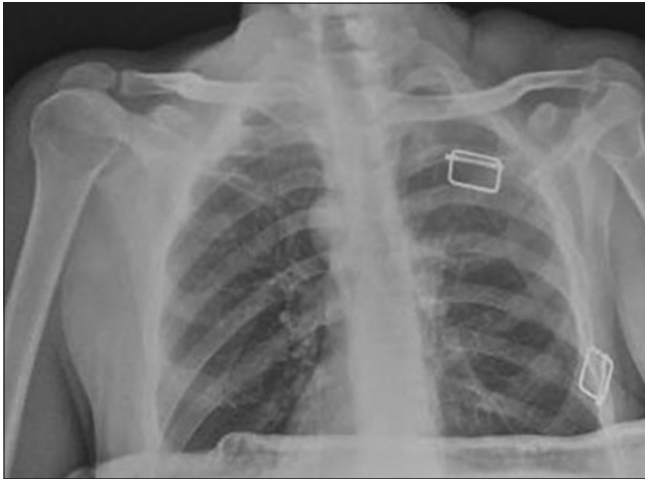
Postoperative plain radiograph show reduction of the left sternoclavicular joint.
